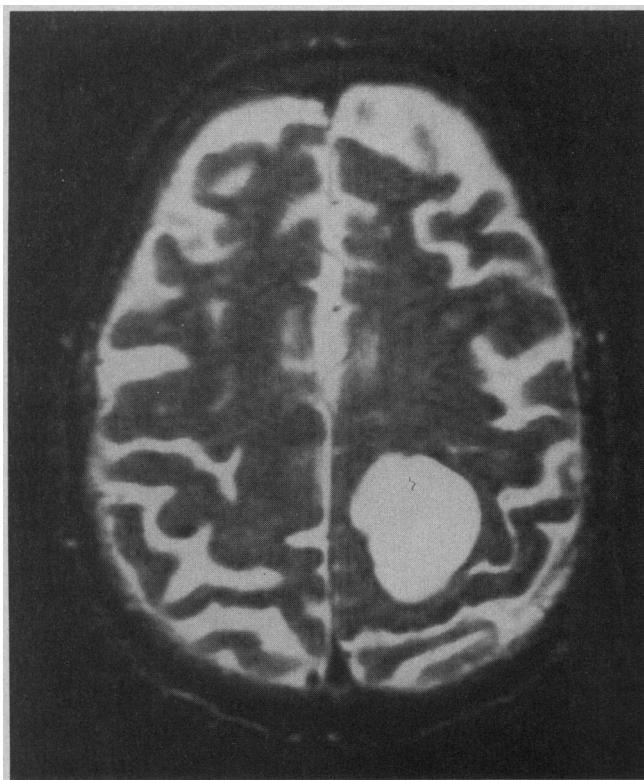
Axial magnetic resonance imaging scan showing intraparenchymal tumor (contrast gadolinium enhanced).
